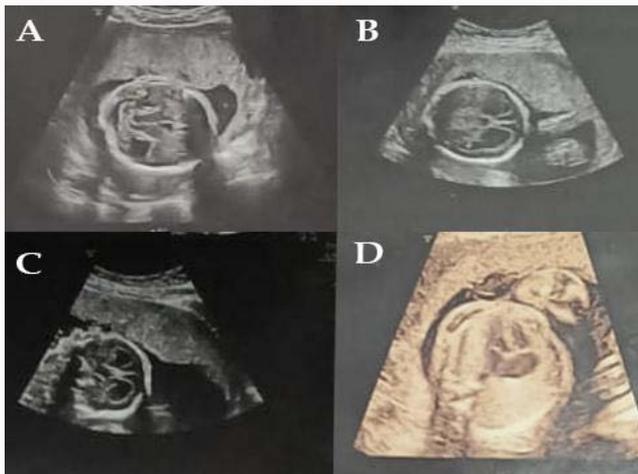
1D: Ultrasound imaging showing tri-ventricular dilatation without other cerebral abnormalities.
